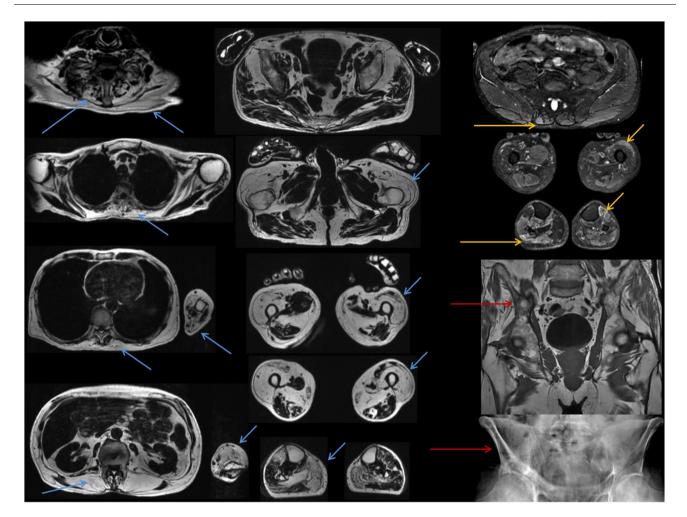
Whole-body muscle MRI in a patient with VCP myopathy (Axial T2 Dixon "Fat" and "Water" images, coronal T1 and frontal plain radiograph of the pelvis, Imaging Department, Raymond-Poincaré Hospital, AP–HP 2022). Note the symmetrical involvement (blue arrows) of the axial paraspinal muscles (extensors more severely than rotators), the shoulder girdle (trapezius, subscapularis), the deep common flexors of the fingers in the upper limbs and, in the lower limbs, the quadriceps, the gastrocnemius medius and the anterolateral compartment of the leg. T2 hyperintensity are noted in the paraspinal right muscle at lumbar level, the left vastus lateralis, the right lateral gastrocnemius and the left anterior tibialis (yellow arrows). This patient also presented a bone involvement with Paget disease of the right ilium (red arrows).
